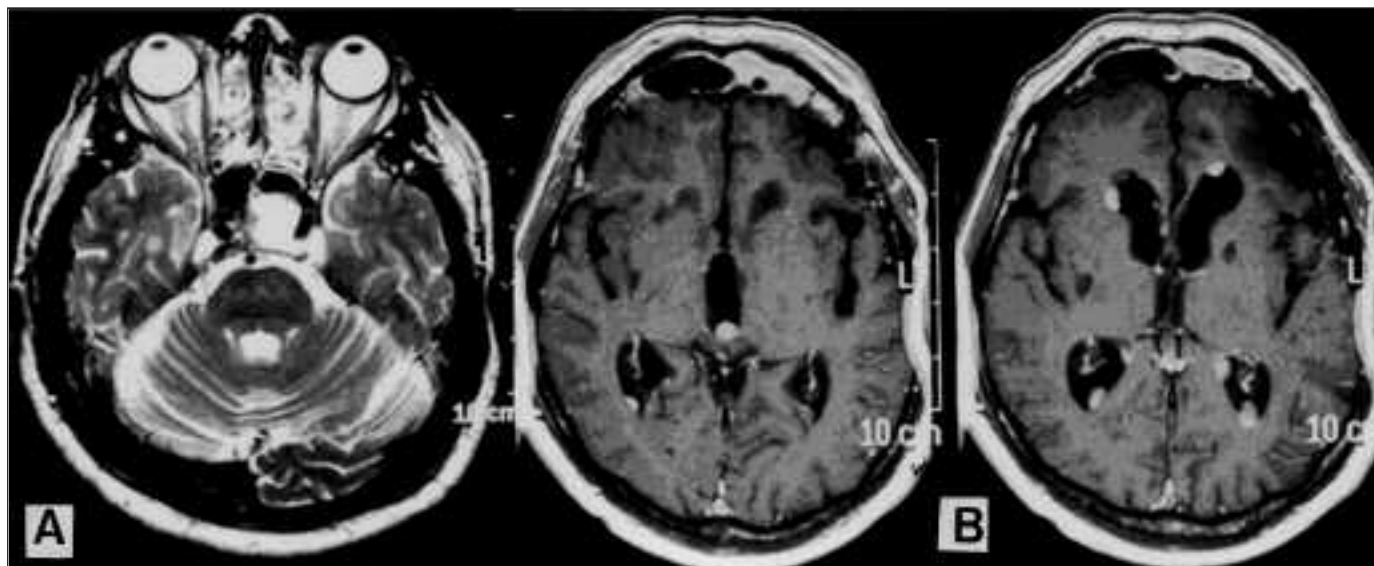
(A) Axial T2 weighted MR images depicting CSF-signal filling area of previous pituitary adenoma resection. No sellar or suprasellar mass is seen. Incidental ethmoid sinusitis is present. (B) Gadolinium enhanced axial T1-weighted MR images demonstrate multiple homogeneously enhancing nodules of variable size lining the ventricular surfaces and surfaces of the choroid plexus.
